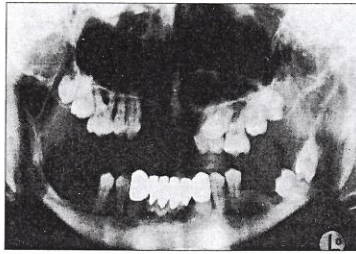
Panoramic radiography of the patient at age 25 9/12. Multilocular radiolucencies in the right ramus after extraction of impacted third molar and biopsy. Stabilization of alveolar bone destruction after exfoliation of mandibular right molars.
